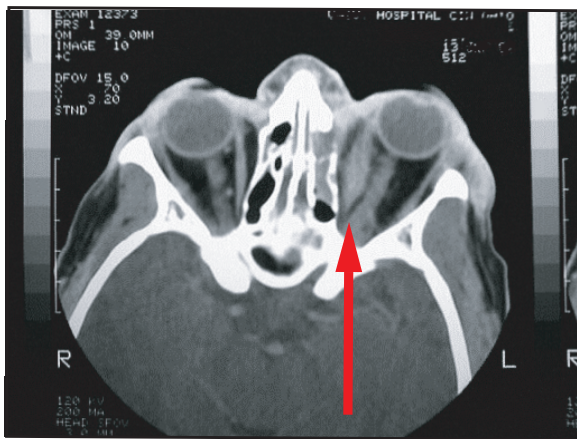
CT scan Orbit showing left eye involvement
